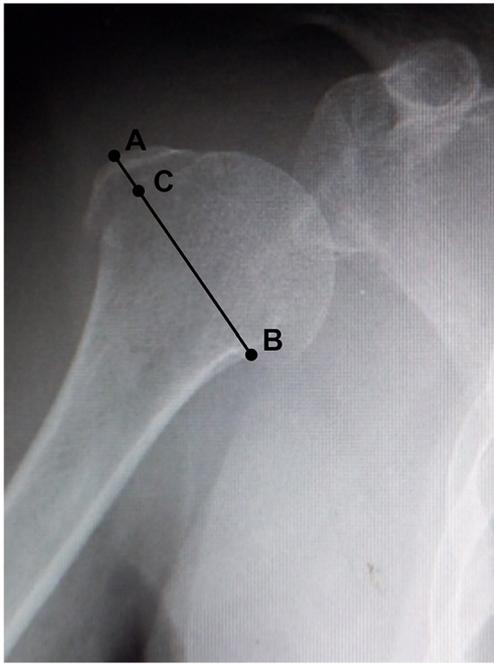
In an AP view X-ray of the shoulder, define three points. Place Point A at the vertex of humeral greater tuberosity, point B at the maximum curvature of the medial cortex between the humeral surgical neck and anatomic neck, and point C at the fracture line where it crosses the line segment AB
